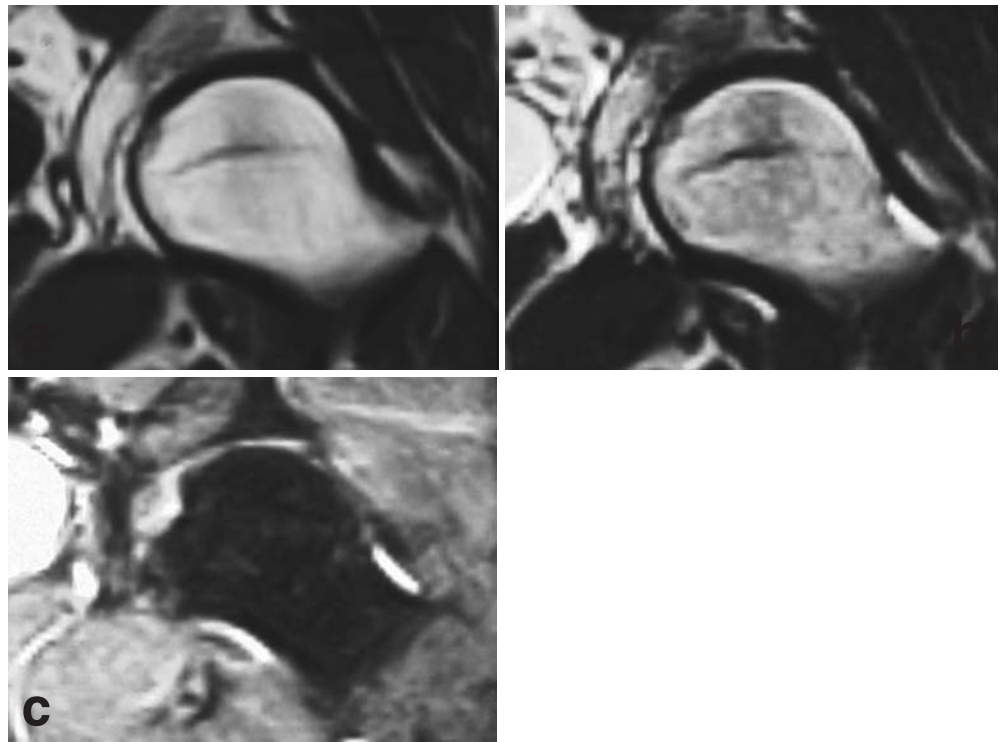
MR images 7 months after onset. The bone marrow edema pattern is considerably diminished on the T1-weighted image (a), the T2-weighted images (b), and the fat suppression image (c)
